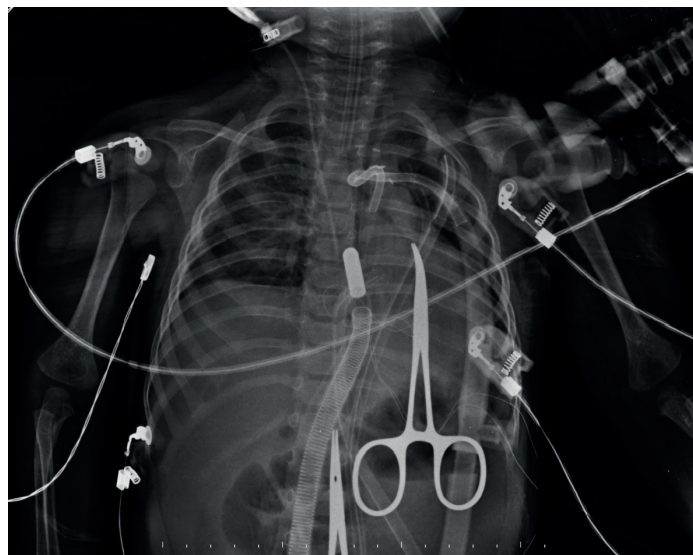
Chest radiograph of this patient during ECMO support
